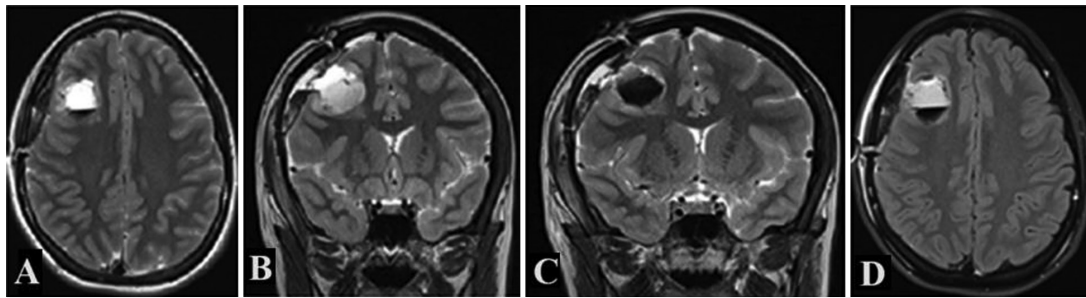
Immediate postoperative axial T2-weighted (A), coronal T2-weighted (B and C), and axial FLAIR (D) MR images demonstrating air-fluid levels in the postsurgical cavity and an extra-axial hemorrhagic collection.
